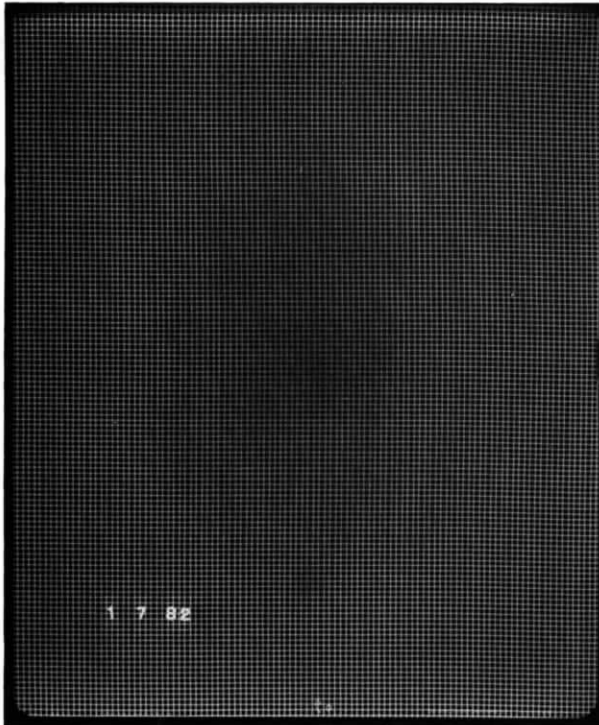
Unacceptable contact is exhibited in this screen as a large dark area in the center of the radiograph of the mesh. This cassette should be repaired or replaced.
